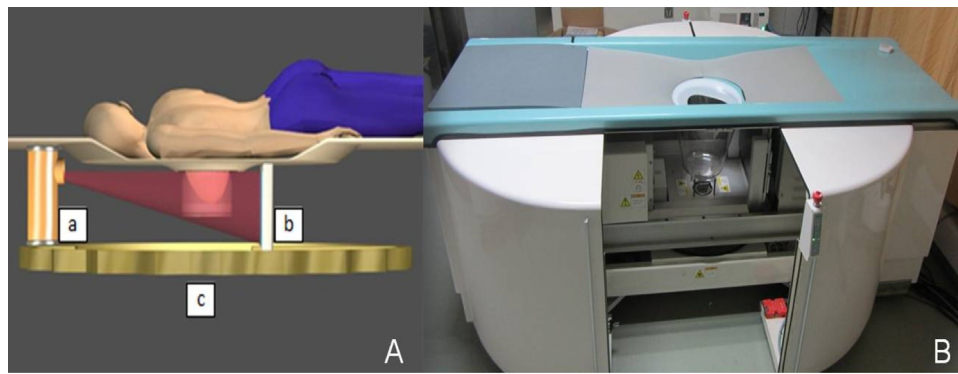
Breast cone-beam CT.
